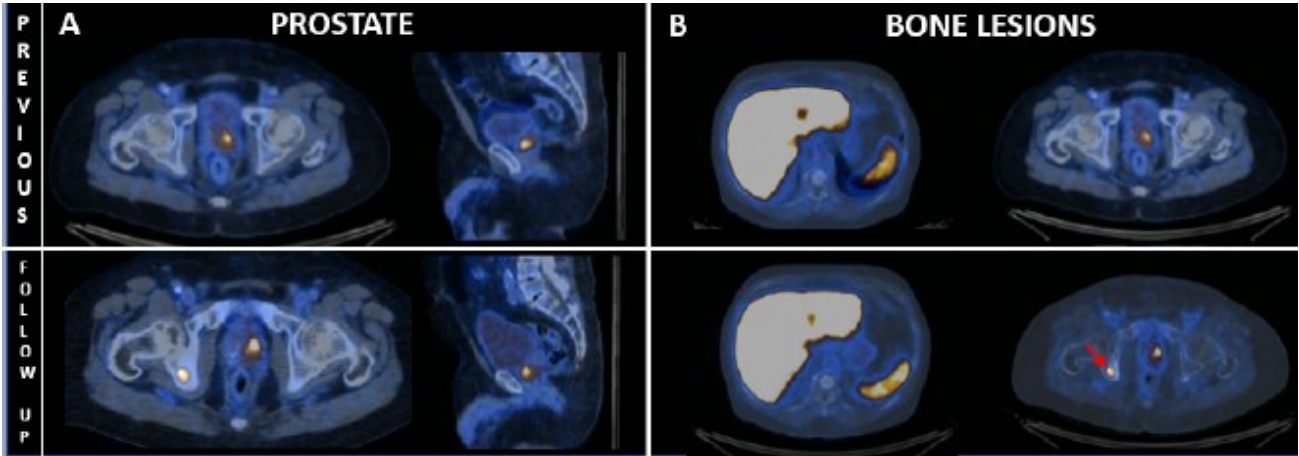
Comparison of serial fused F-18 PSMA PET/CT images captured during follow-up.
